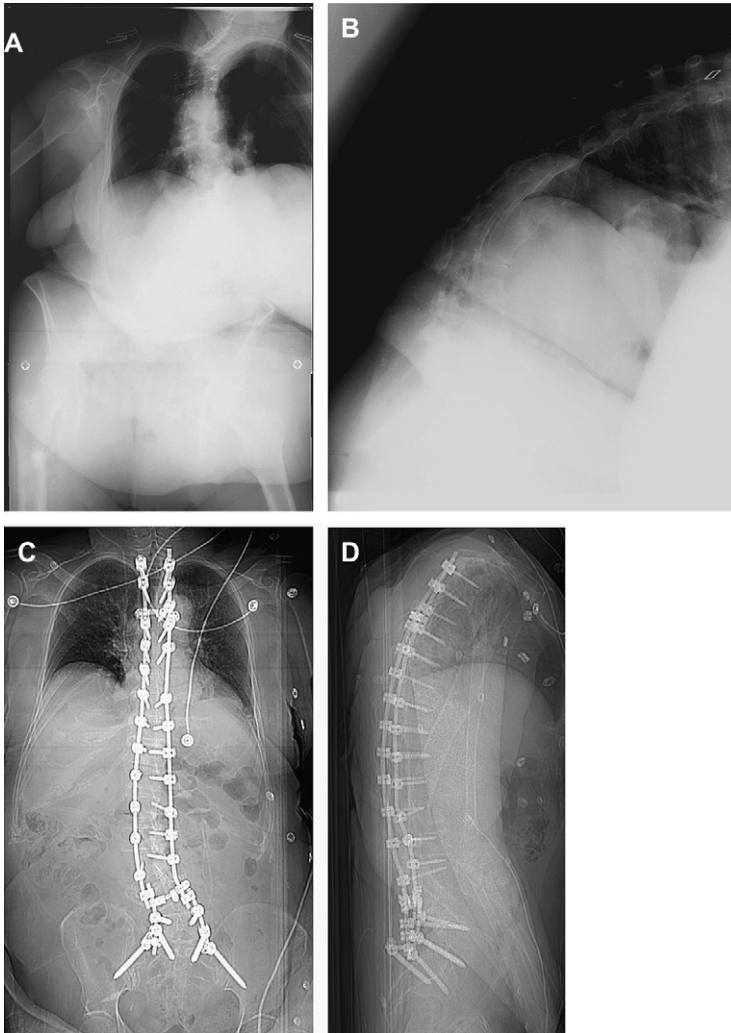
Radiographs of a 63-year-old woman with severe kyphoscoliosis. Radiographs before surgery: anteroposterior (AP) view (A) and lateral view (B). Radiographs after surgery with correction using the rod rotation maneuver: AP view (C) and lateral view (D).
